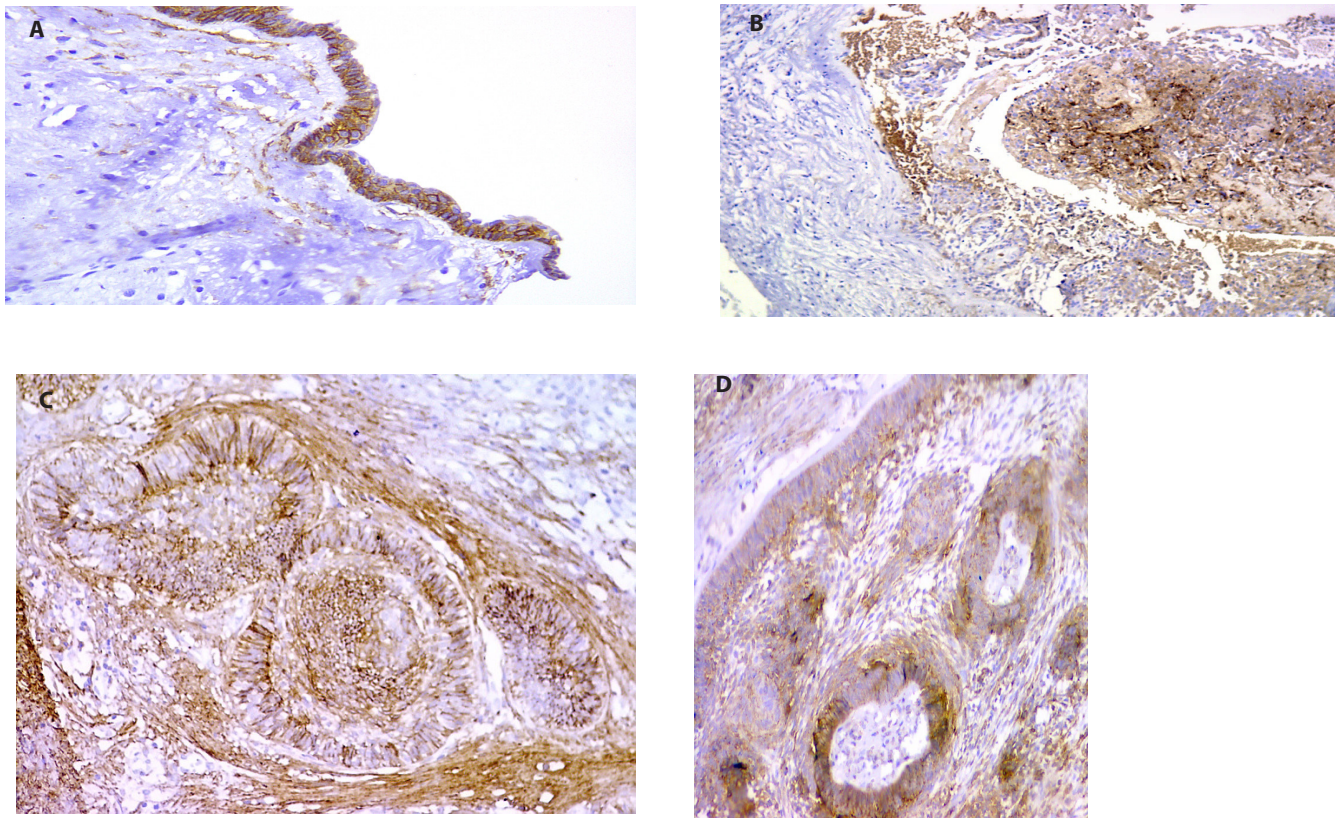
(A) Dentigerous cyst case showing; membranous and cytoplasmic immune positivity to Syn1E in the cyst lining epithelium and low Syn1S expression in the cytoplasm of fibroblasts in the CT (Syn1, PAP-DAB, 200X). (B) Unicystic- L/I Ameloblastoma showing the expression of Syn1 restricted to the luminal and intaluminal cystic epithelial contents with negative stromal reaction in the cyst wall (Syn1, PAP-DAB, 100X). (C) Follicular Ameloblastoma with Strong diffuse membranous and cytoplasmic Syn1 expression (Syn1, PAP-DAB, 100X). (D) Ameloblastic Carcinoma cases showing: Diffuse cytoplasmic expression of Syn1 in the epithelium and CT (Syn1, PAP-DAB, 100X).
